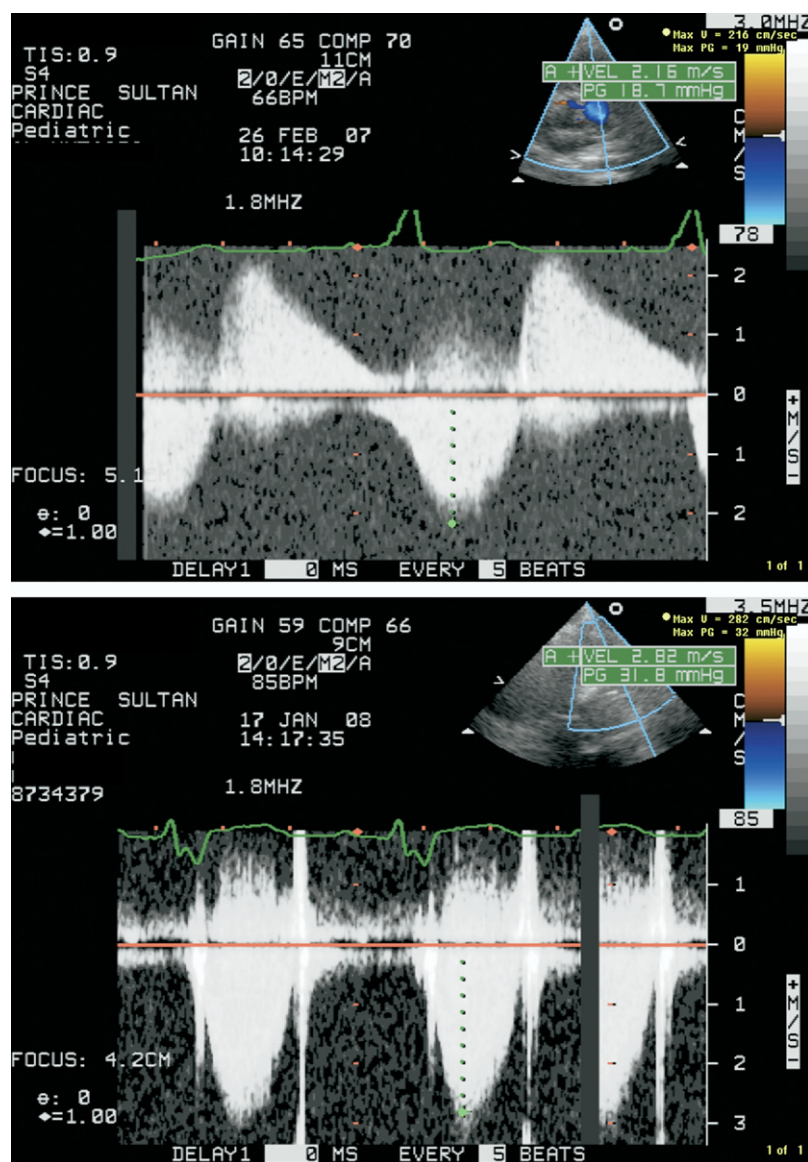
Continuous-Wave Doppler Tracing of the Pulmonary Valve
